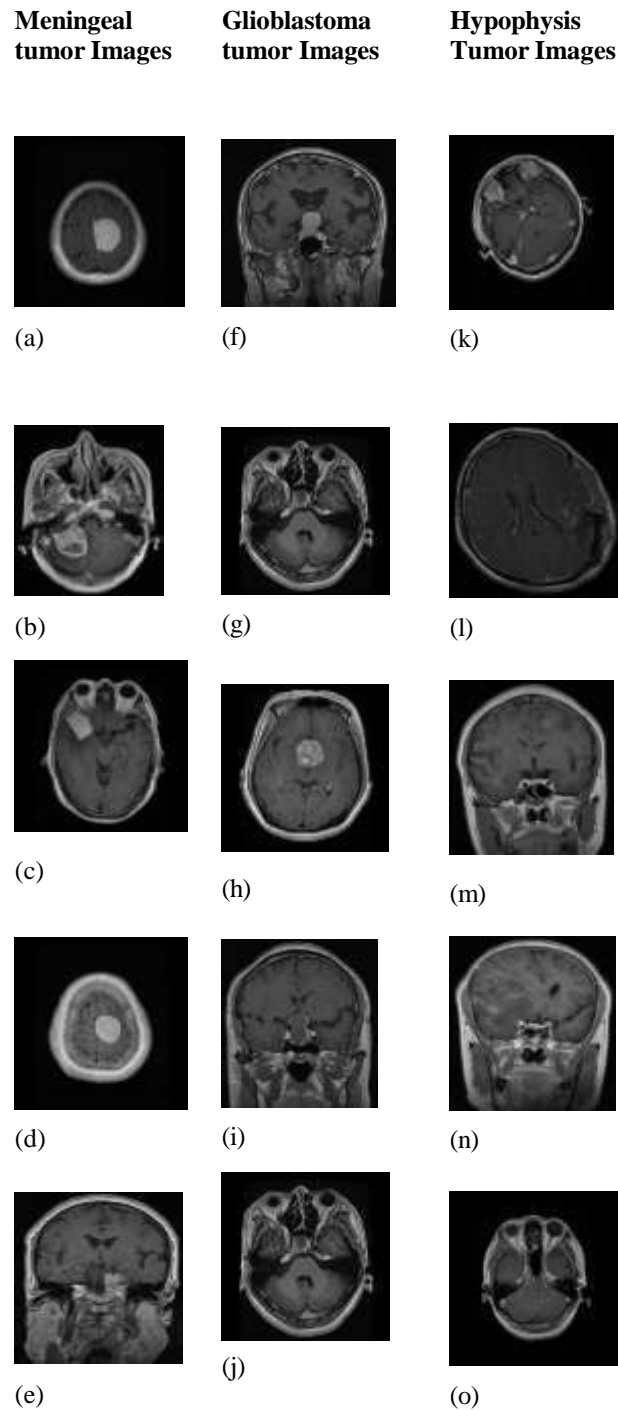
Examples of test MRI images from a tumor dataset with various forms of weighted contrast enhancement (a)-(g) Meningioma ,(h)-(n) Pituitary tumor, (o) Glioma
